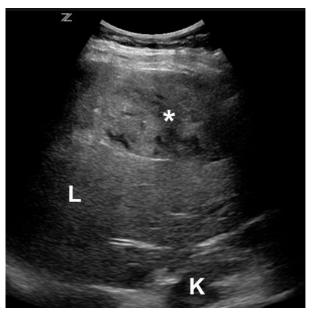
Emergency physician-performed ultrasonography showing hyperechoic mass in liver. L = liver; K = kidney; \* = hyperechoic mass.
